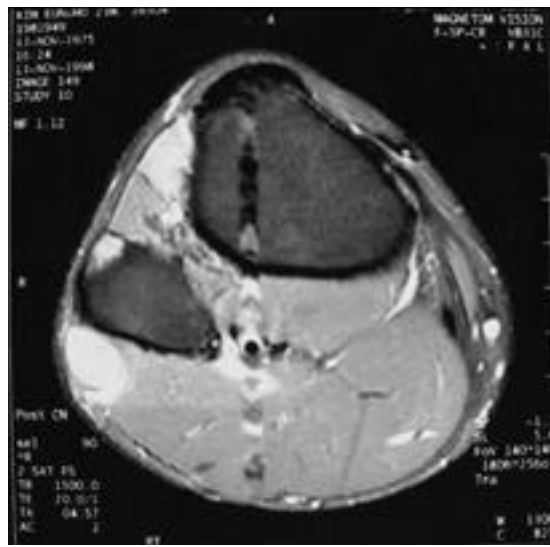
Gadolinium-enhanced T1-weighted images (TR/TE: 1500/20) at the same level as Fig.1 showing peripherally enhanced cyst.
